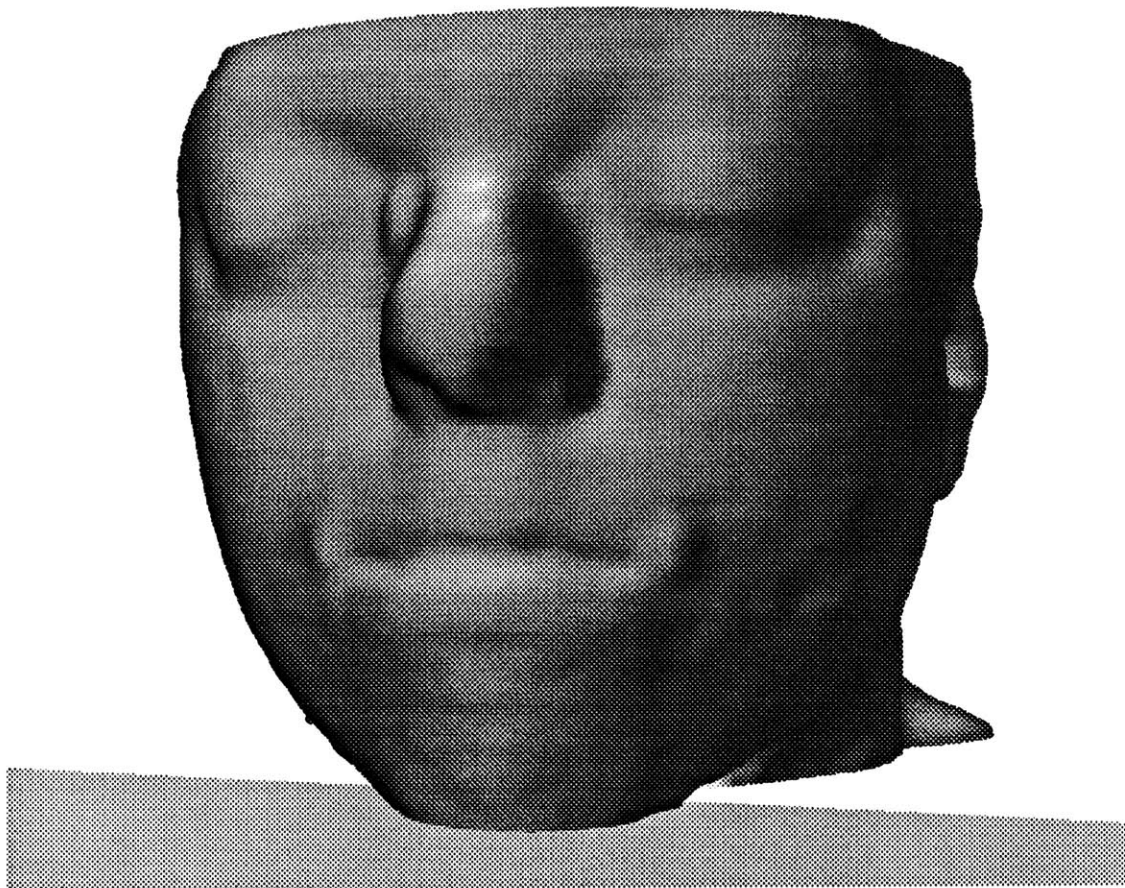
Skin surface reconstructed from CT scan.
